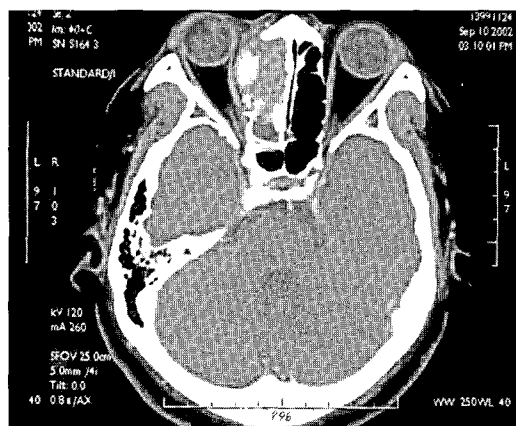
Computed tomography revealing a mass in the ethmoid sinus with extension into the medial aspect of right orbit.
